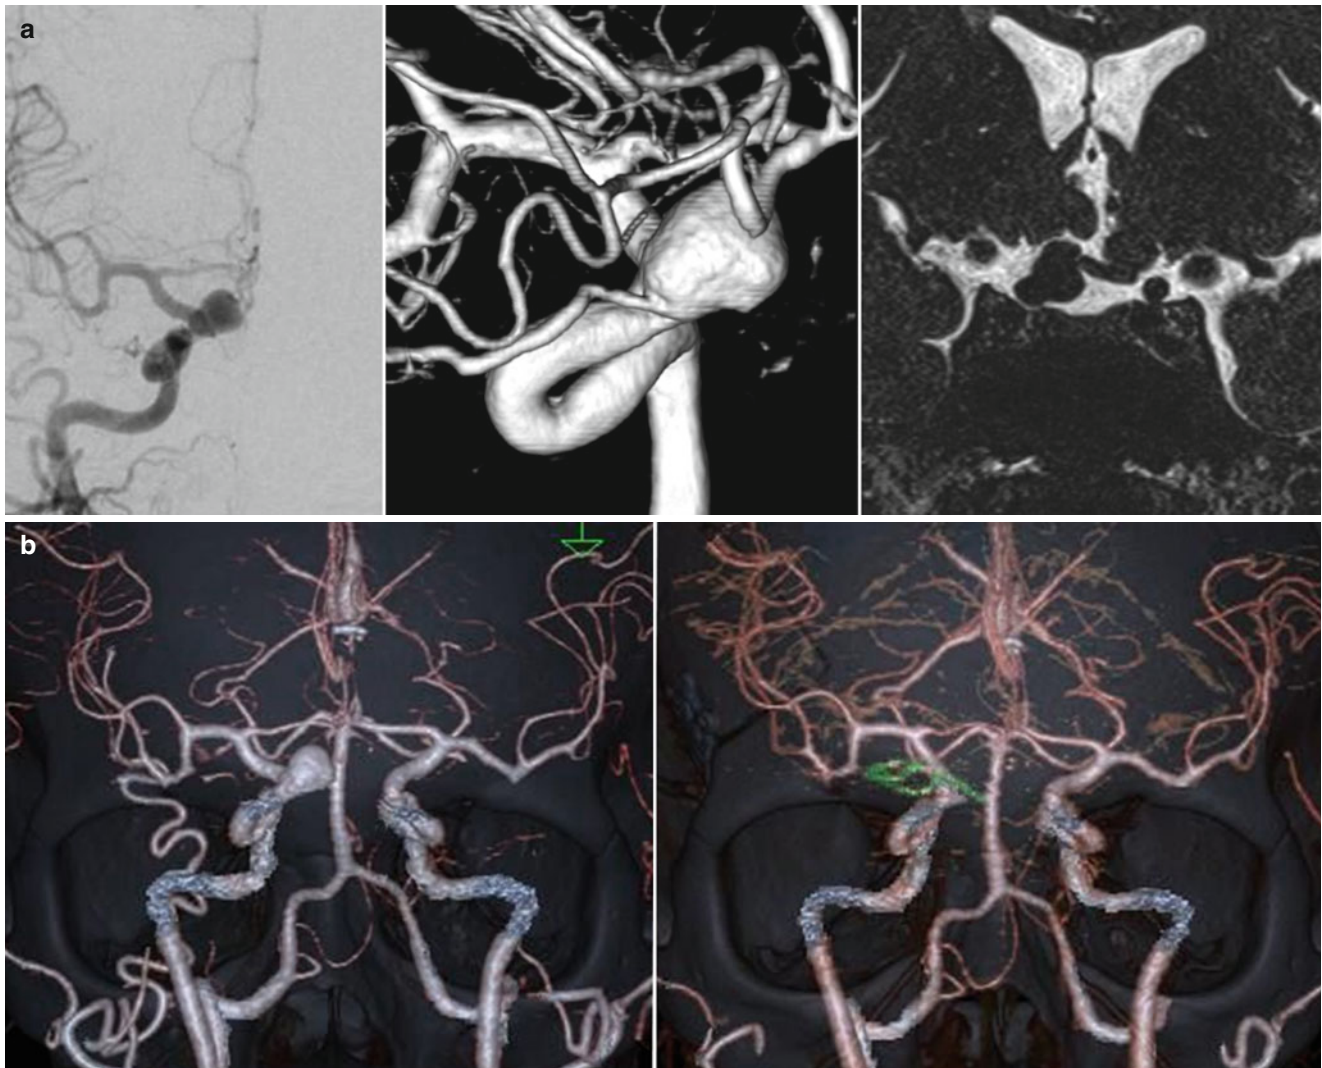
(a) Antero-posterior (*left*) and oblique (*center*) projections of right carotid angiograms showing the aneurysm projecting superomedially and the ophthalmic artery originating from the aneurysmal dome. Coronal section of magnetic resonance imaging (*right*) showing
